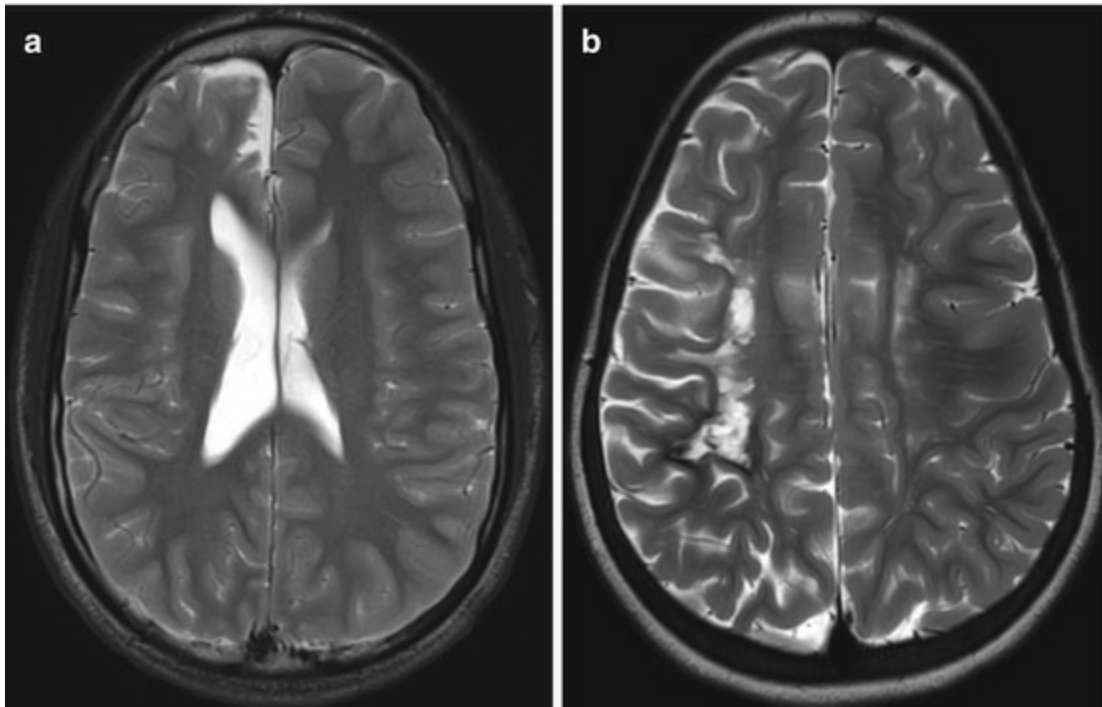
CT scans of patient with SCD and a stroke in the (a) anterior cerebral artery and (b) middle cerebral artery distribution. There was prior MRA evidence of severe cerebral vasculopathy with stenosis in both cases
